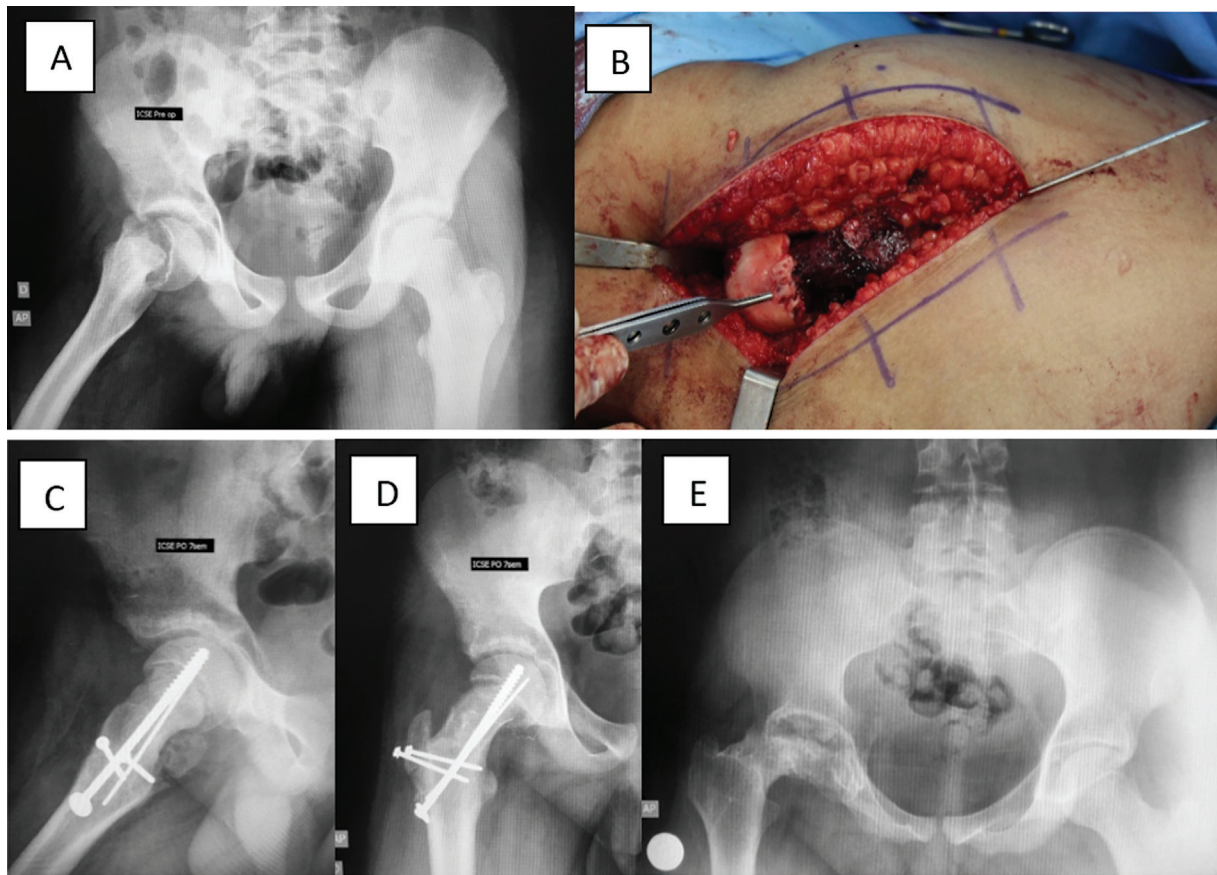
Preoperative period (A); intraoperative aspect of the footprint of the retinacular vessels in the epiphysis demonstrating its potential avulsion due to the slip (B); immediate postoperative period (C,D); and final (E) radiographic aspect of a severe unstable slip developing avascular necrosis of the femoral head.
